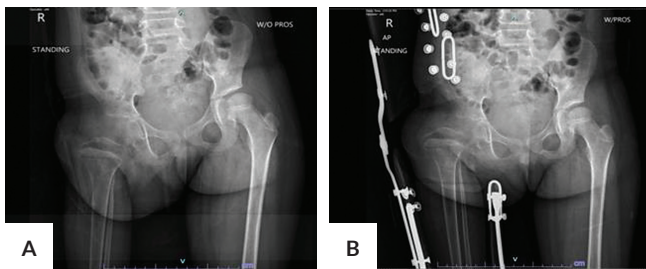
Standing pelvic radiograph on AP view (A) without and (B) with prosthesis. The patient's right femur was surgically resected, the tibia was rotated 180 degrees and was placed into the acetabulum. The X-ray confirmed that the lateral tibial condyle is in place and had remodeled to from a neo-hip that resembles that of a developing femoral head.
